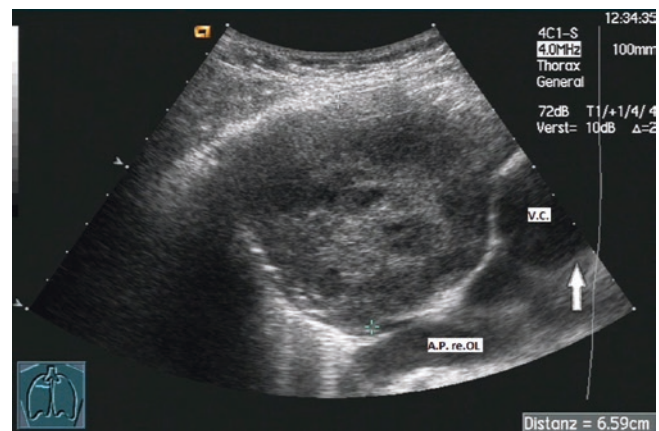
Space-occupying lesion in the upper and middle lobe with several necrotic zones (*arrowheads*). Initially there were marked signs of inflammation on clinical examination. Under antibiotic therapy the invasive pneumonic portion resolved (*arrow*). Sonographic biopsy from solid portions of the space-occupying lesion indicated squamous cell carcinoma
